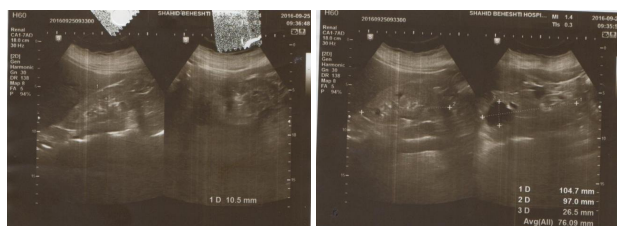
Sonographic view of kidneys. Renal ultrasound scan is indicative of normal sized kidneys (L: 99, R: 98) with 3 cysts in the upper pole of the left kidney with different sizes (2, 10, and 26 mm).
